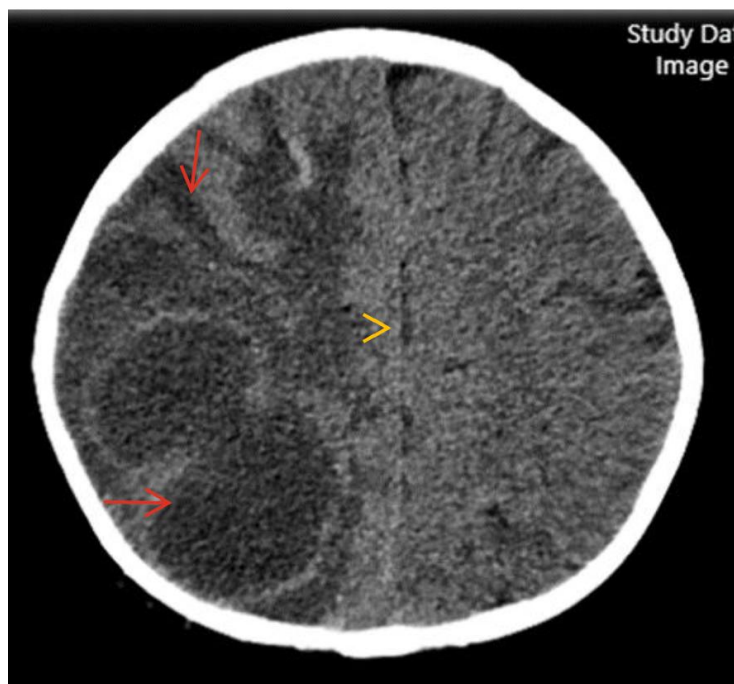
Brain CT scan showing a right parieto-occipital multiloculated abscess (4.5×5 cm) with severe perilesional edema (arrow), 8-mm midline shift (arrowhead), and left lateral ventricular dilation.
